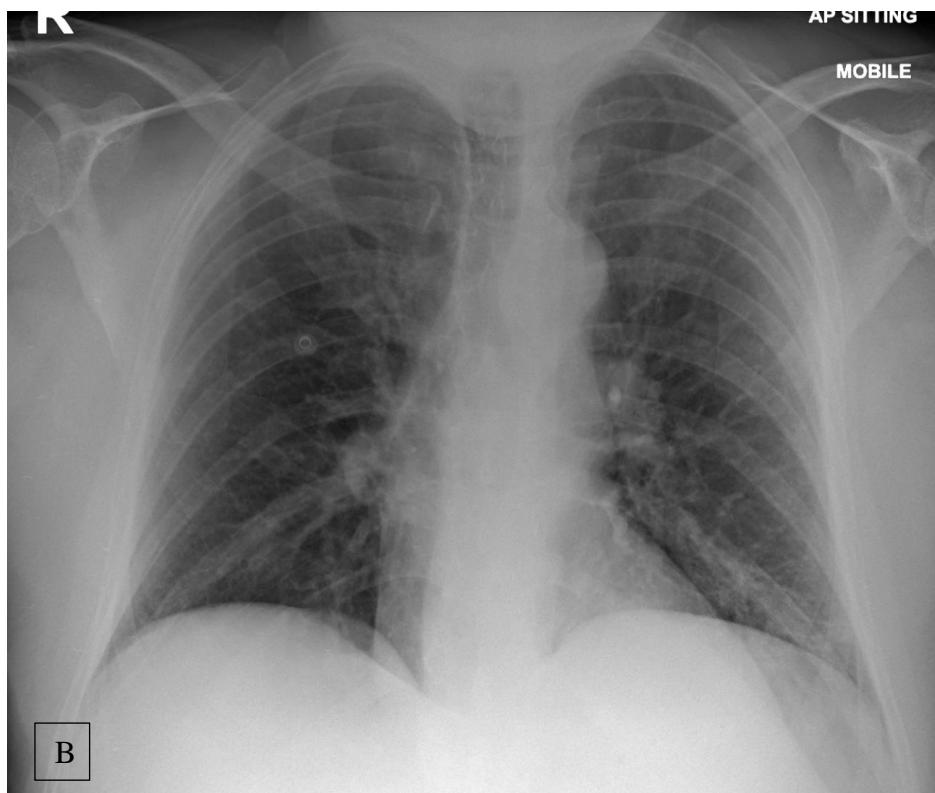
Chest Radiograph of Hospitalized Covid-19 Patients. A. Young man with positive Covid-19, chest radiograph showing air space pattern of opacities in middle and lower zones with prominent peripheral zonal involvement. B. Peripheral Left lower zone linear pattern of opacities. C. Multiple diffuse nodular pattern of opacities in Covid-19 patient who was eventually admitted to ICU.
